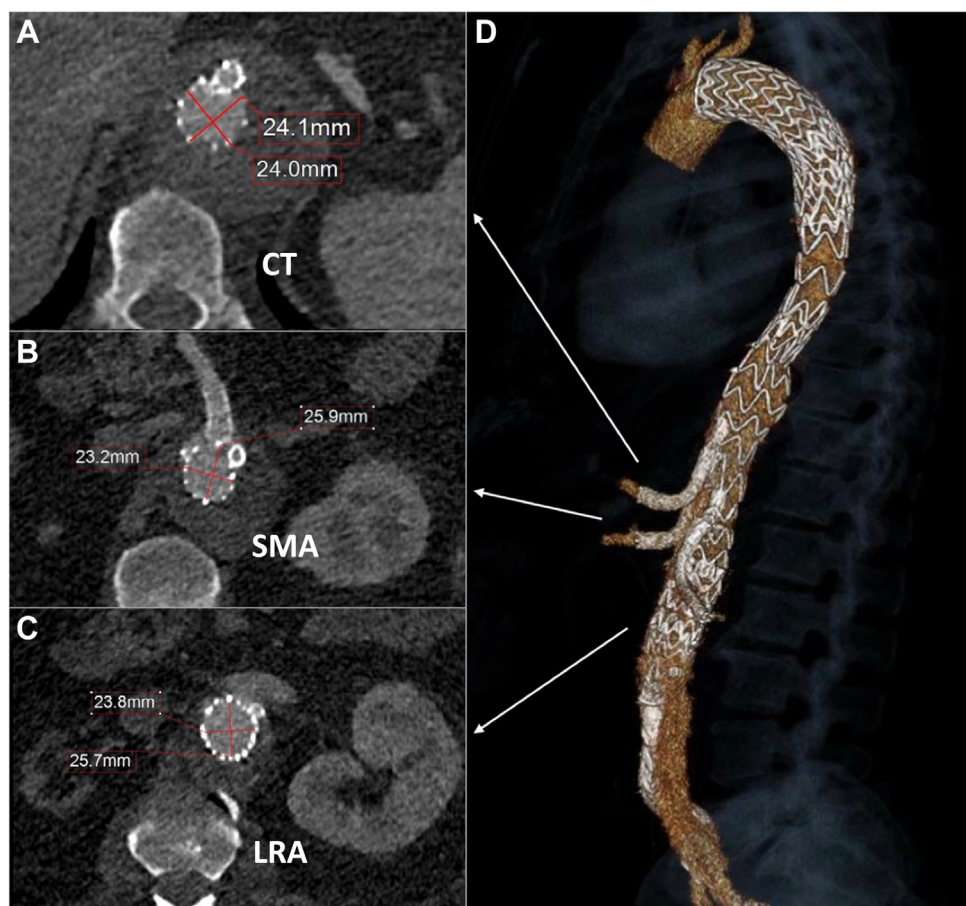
(A) Axial postprocedure computed tomography angiogram (CTA) of the aorta at the celiac trunk (CT) level; note the early positive aortic remodeling with complete false lumen thrombosis. (B) Aorta at the superior mesenteric artery level; note the complete main graft expansion at its nominal diameter (24 mm) and no signs of compression on bridging stents. (C) Aorta at the left renal artery level. (D) Three-dimensional CTA reconstruction of the entire endovascular repair. SMA, Superior mesenteric artery; LRA, left renal artery; CT, celiac trunk.
